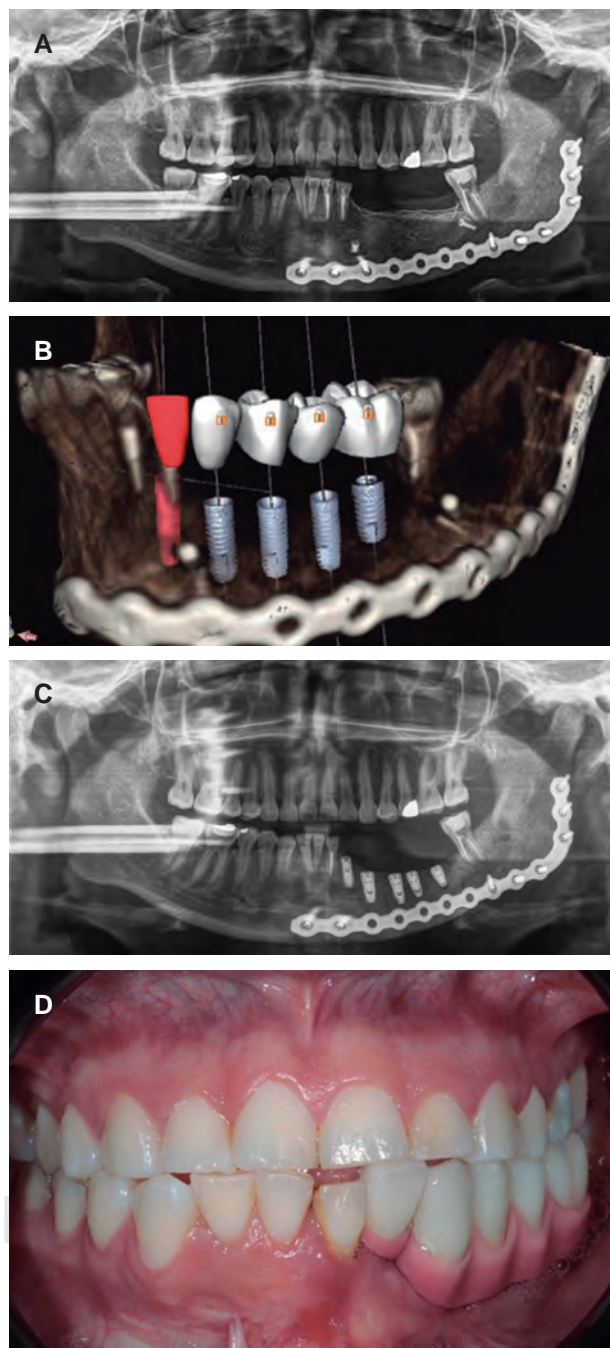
A) Orthopantomography after lyophilized bone graft and titanium mesh placement. B) Three-dimensional planning for implant placement. C) Control orthopantomography after dental implant placement. D) Implant supported overdenture.
